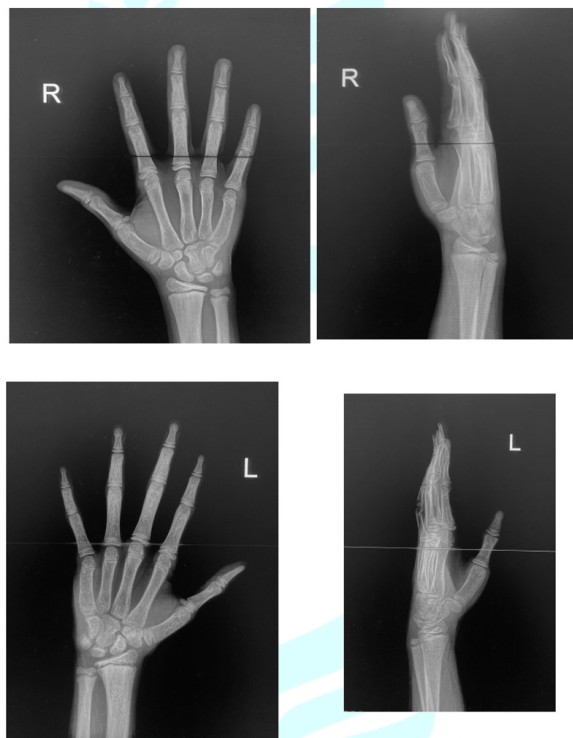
X-Ray of the Hands- (AP/LAT).
